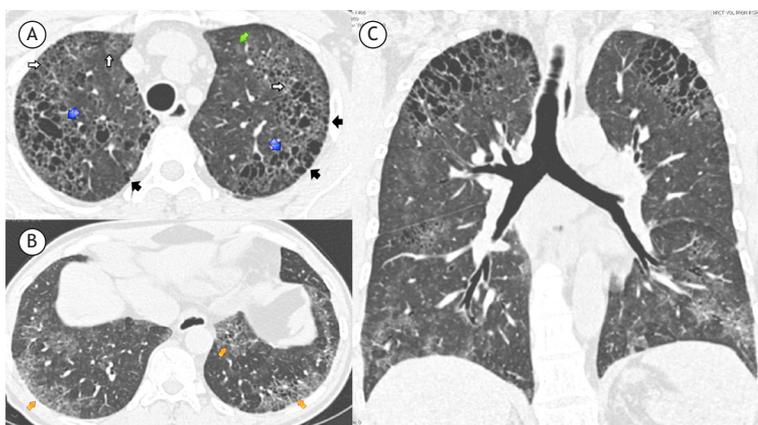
HRCT scan of the upper lobes (A), showing poorly defined micronodules (green arrow), with subtle pseudocystic airway changes (blue arrows) and mild patchy septal thickening in the upper lobes (white arrows). Ancillary findings were rare centrilobular and paraseptal emphysema (black arrows) and bronchial wall thickening. HRCT scan of the lower lobes (B), showing patchy ground-glass opacities with fine reticular elements and containing very small areas of bronchiolectasis (orange arrows). Coronal reconstruction (C) better demonstrates the coexisting patterns described in the HRCT axial scans.
